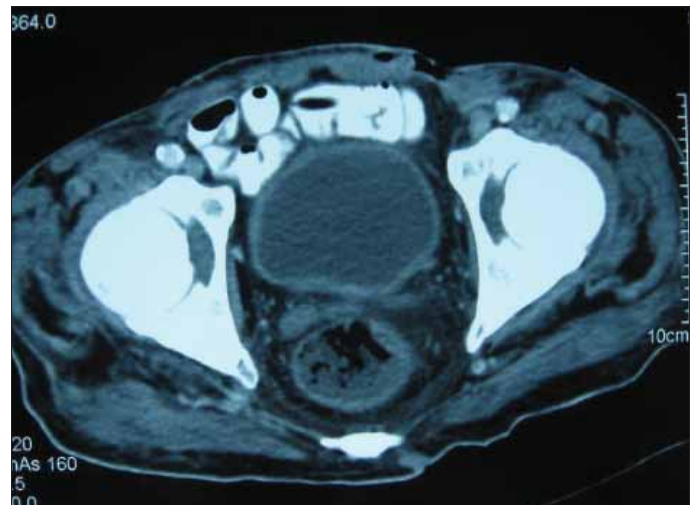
Computed tomography of the urinary bladder demonstrates normal thickness
